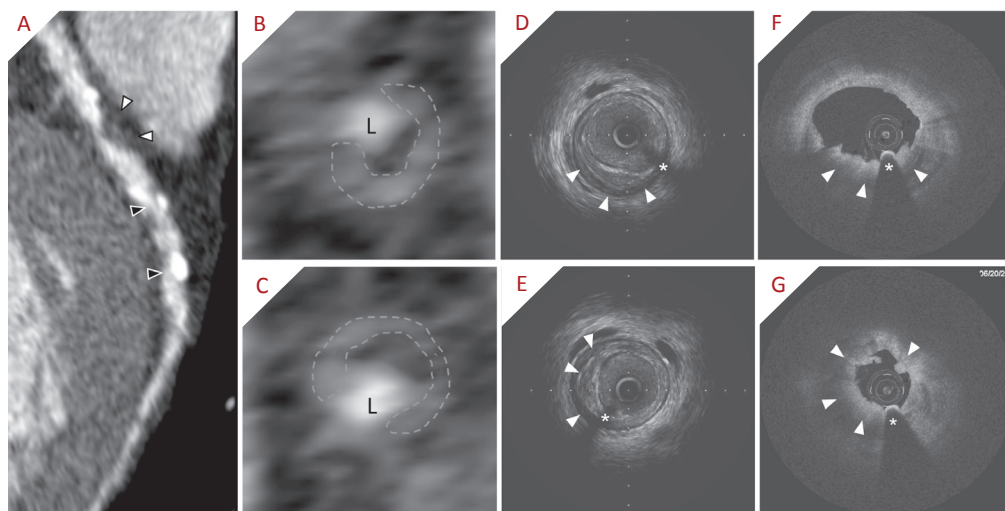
An example of a lesion in left anterior descending artery with corresponding cross-sections on computed tomography, intravascular ultrasound and optical coherence tomography. Multiplanar reformatted image of the left anterior descending coronary artery (A) with a mixed plaque with large non-calcified portion (white arrowheads) and some calcified plaques more distally (black arrowheads). The cross-sectional computed tomography images (B, C) show a coronary plaque with napkin-ring sign attenuation pattern (L = lumen). The circumferential outer rim (dashed blue line) has a higher contrast attenuation as compared to the inner part of the plaque. Intravascular ultrasound (D, E) images show a predominantly fibrous plaque (white arrowheads). Optical coherence tomography (F, G) of the corresponding cross-sections shows (mural) thrombus in both positions (white arrowheads). * represents the shadow of the guidewire.
